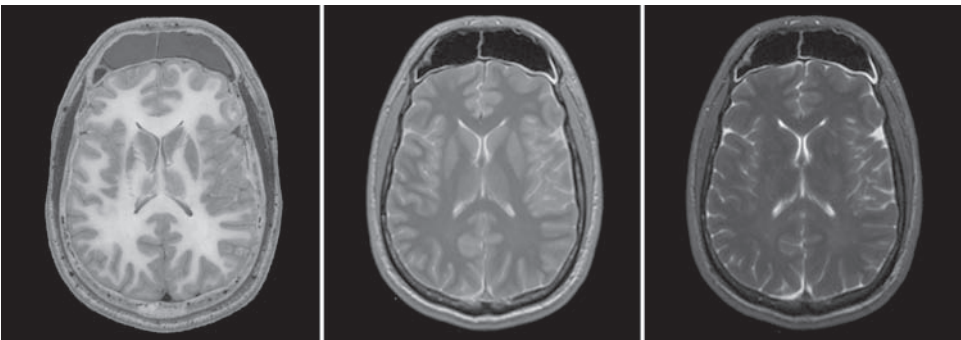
The left horizontal section is from a postmortem brain. Note the anatomical detail provided by MRI at the same level via two different acquisition techniques, each with different properties in displaying underlying anatomy. The middle image is a proton-density axial image in which differentiation of white and gray matter can be visualized. The right image is a T2-weighted axial image in which cerebrospinal fluid is readily identified.
